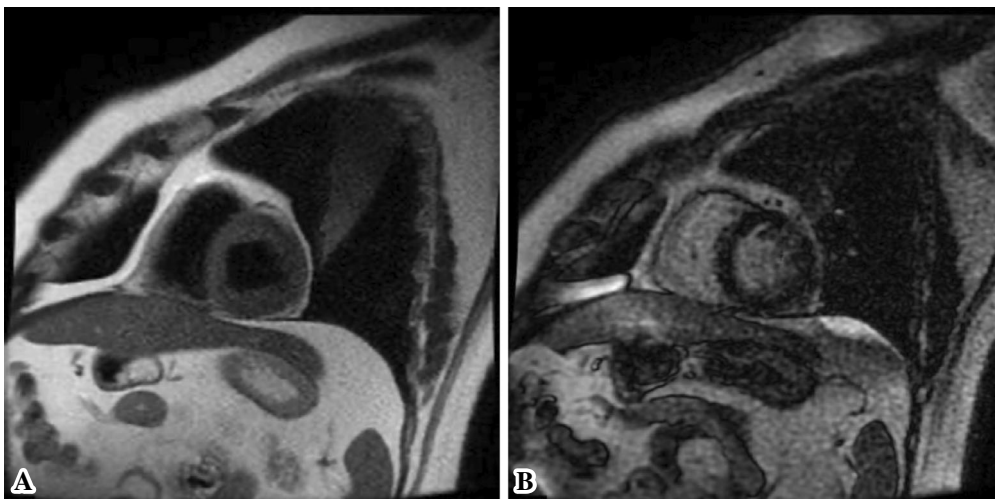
(A) T2-weighted cardiac magnetic resonance imaging showing no obvious myocardial edema. (B) Late gadolinium enhancement is not seen.
